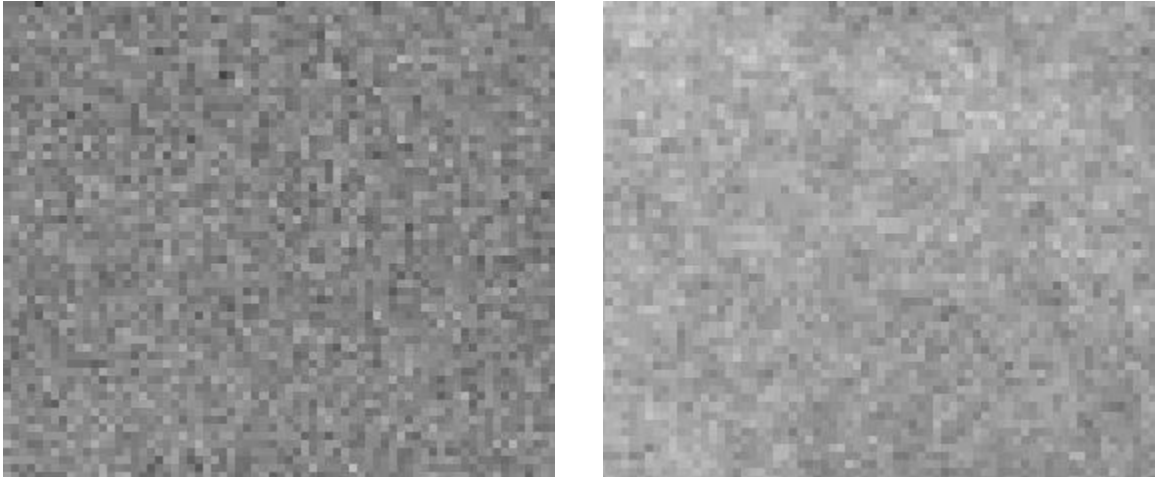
Example of image noise at 4x magnification from a Shimadzu Safire II direct radiography system (left) and a Kodak CR 800 indirect radiography system (right).
